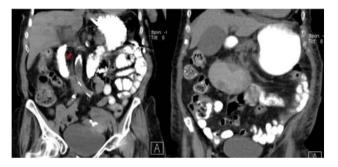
Comparison of the abdominal CT scan at the followup at one month (left) and the initial CT scan (right). The red arrow shows the free passage of the oral contrast through the duodenum and the complete resolution of the hemobezoar.
